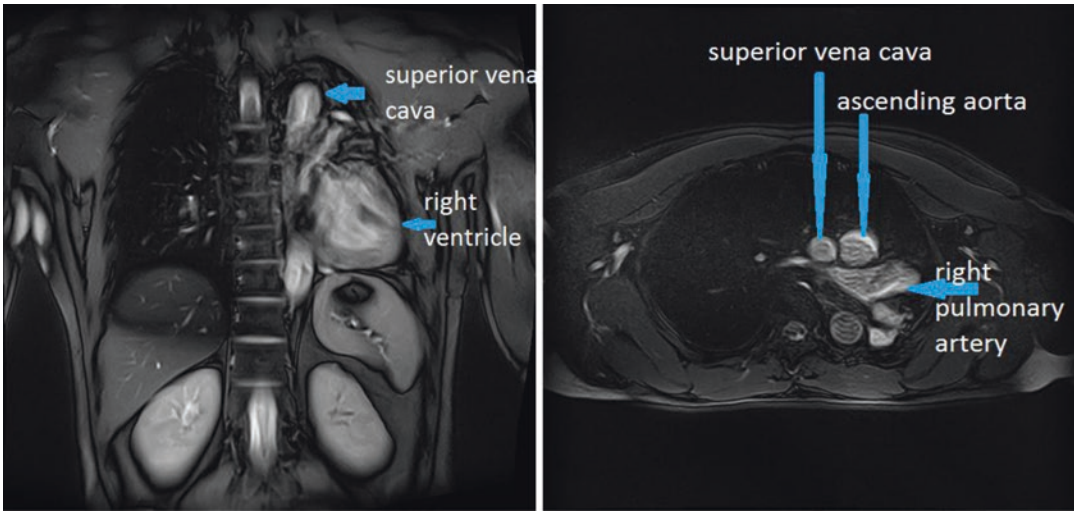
Thoracic MRI—left pneumonectomy with cardiac displacement on the left side (4 years follow-up)
